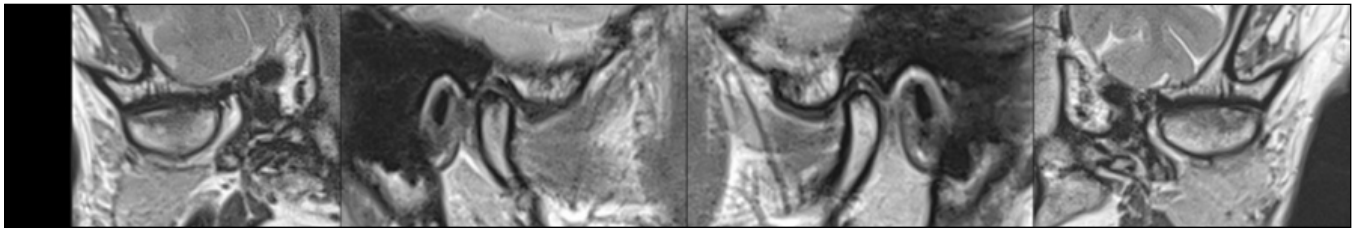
MRI-TMJ _right and left in the paracoronal and parasagittal planes
